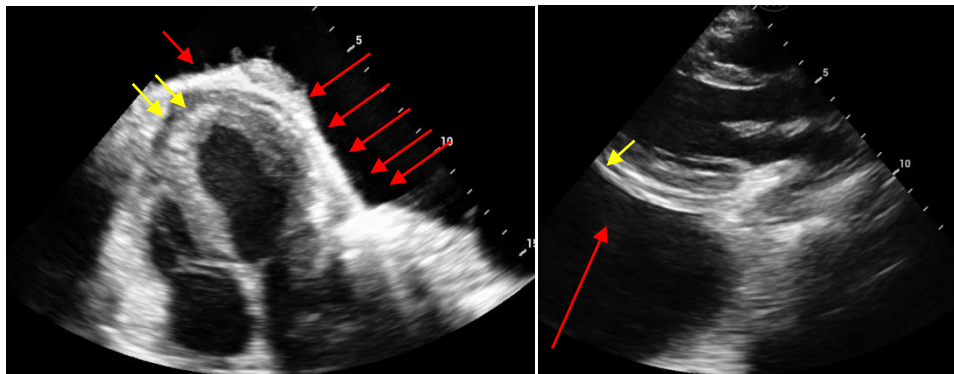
Echocardiography A: Para-sterna long axis four-chamber view Showing massive pleural effusion looking like pericardial effusion (red arrow) and minimal pericardial effusion (yellow arrow). B: Parasternal short-axis view minimal pericardial effusion (yellow arrow) and massive pleural effusion (red arrow).
